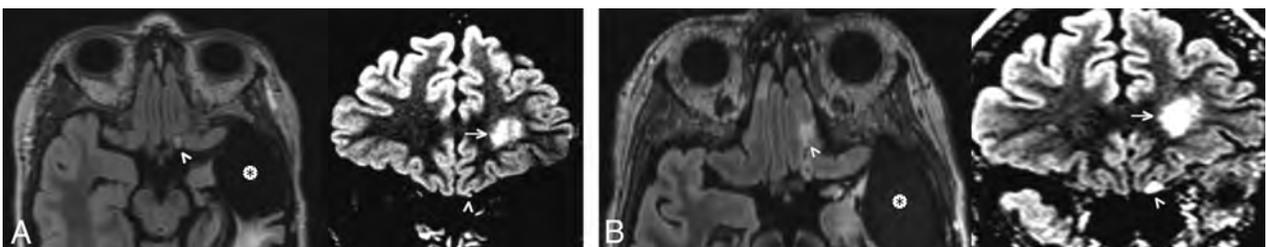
A 46-year-old woman with left inferior frontal grade III diffuse anaplastic oligodendroglioma previously treated with resection and chemoradiation (case 3). Axial and coronal FLAIR images obtained 8 years after the initial treatment (A) demonstrate a left temporal resection cavity (asterisk) and unchanged FLAIR signal in the left frontal lobe (arrow). There is subtle nodular FLAIR signal abnormality (arrowheads) of the left olfactory bulb. Axial and coronal FLAIR images obtained 16 years after the initial treatment (B) show minimal change around the resection cavity (asterisk) but progressive enlargement of the hyperintense left olfactory bulb (arrowheads).
